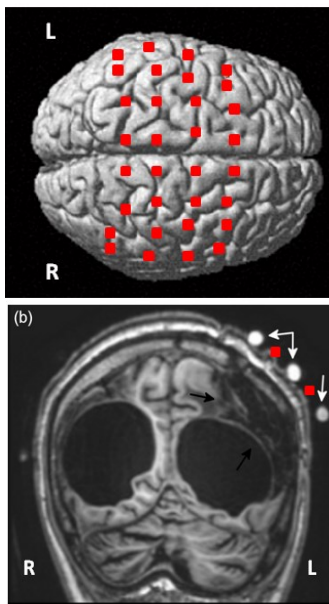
Top: Registration of NIRS montage over a standard cortex (frontal channels for signal quality check are omitted). Bottom: Coronal T1-weighted section of patient B demonstrates severe cortical and subcortical lesion in the left fronto-parietal hemisphere (black arrows). Vitamin E pills pinpoint the NIRS sites of injection and detection over the surface of the skull. Their position allowed the registration of each NIRS channel on MRI scans (white arrows in b)
